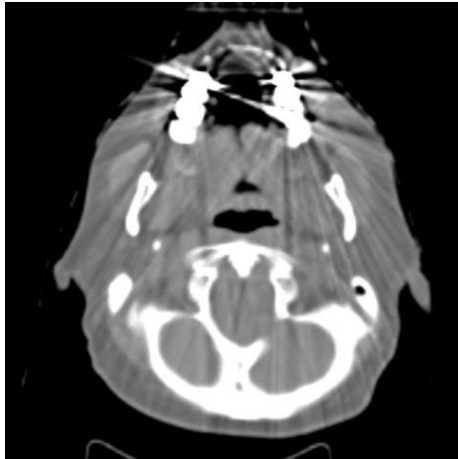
Example of CT image with metal artifacts due to dental filling. It is evident that the quality of the image is worsened and the identification of parotid glands becomes very difficult.
